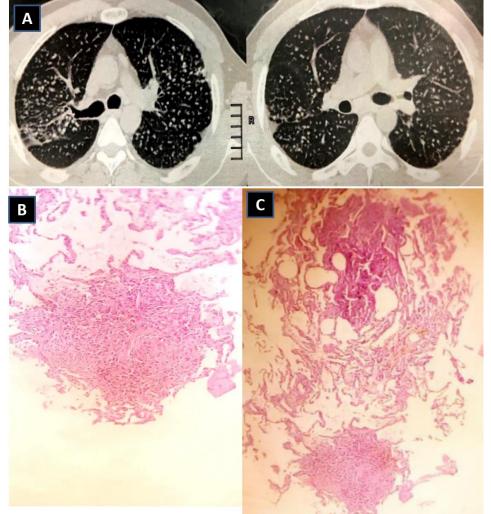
Male patient, 34 years old, smoker, complaining of dyspnea. (A) CT chest showing nodular distribution (Random nodules) as predominant pattern.
